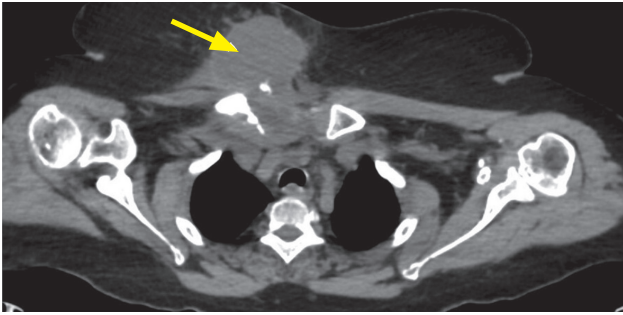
Axial non-contrast computed tomography (CT) thorax shows a well-defined lesion involving the deep subcutaneous plane of the right upper medial chest wall with extension into the pectoralis muscles.
